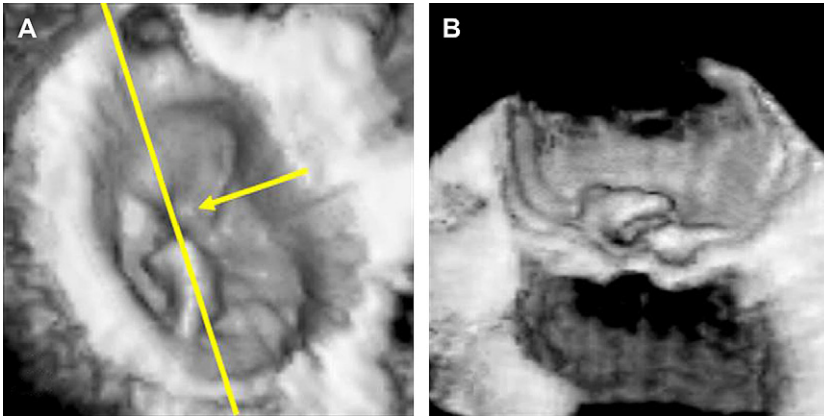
Morphological assessment of mitral valve with 3D echocardiography. (A, B) A transesophageal 3D reconstruction of prolapsed mitral valve. The spatial location and shape of the prolapse can be assessed in the surgical (A) and side view (B). (Courtesy of A. Franke, MD, Aachen, Germany.)
